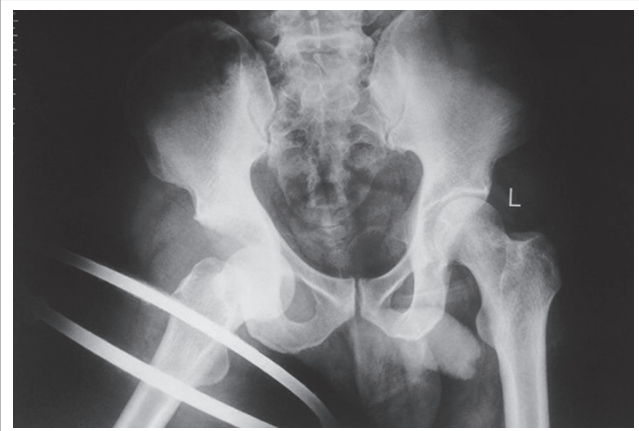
X-ray showing anterior dislocation of hip joint.
